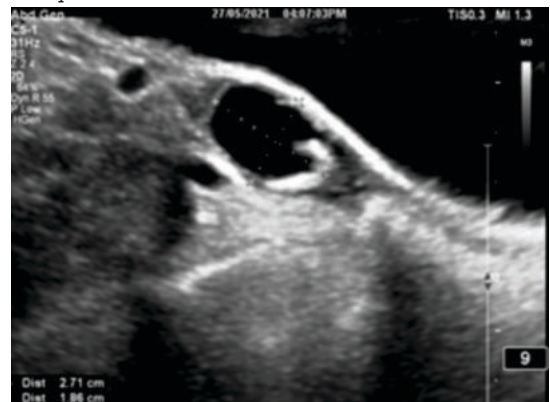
Ultrasonogram Of Pelvis Showing Cystic Ovarian Lesion With Hyperintense Rim
